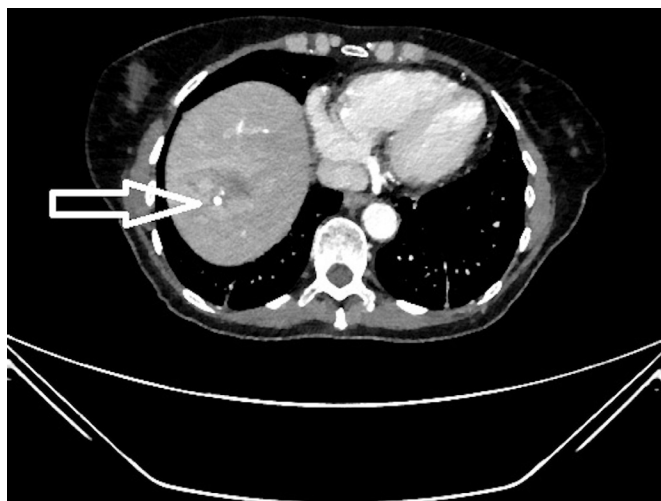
Repeat CT scan showing improvement to liver abscess following percutaneous drainage and antimicrobial therapy. Previously seen consolidation and effusions have resolved.
